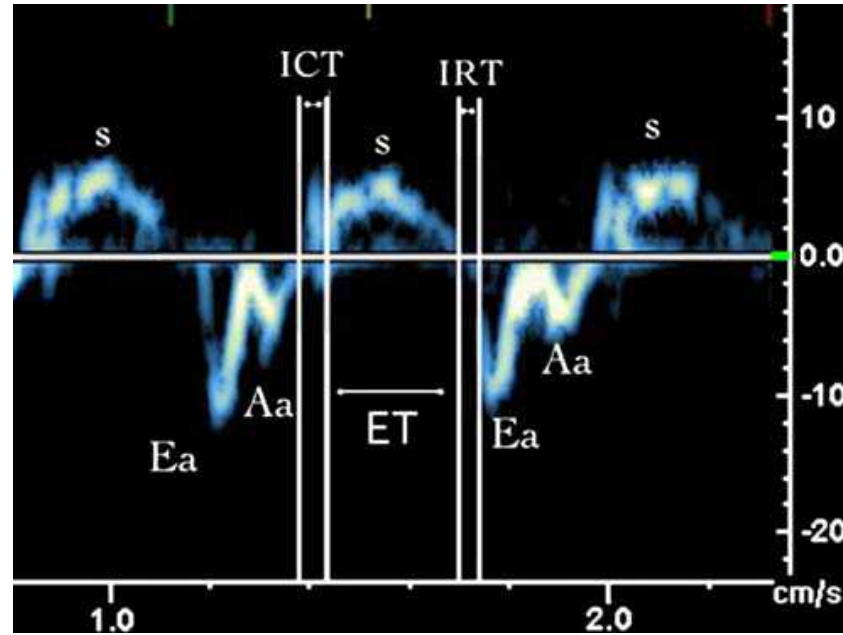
Time intervals measured from pulsed tissue Doppler (*ICT* tissue isovolumetric contraction time, *ET* ejection time, *IRT* tissue isovolumetric relaxation time). TDE-Tei index is calculated as $(ICT + IRT)/ET$
